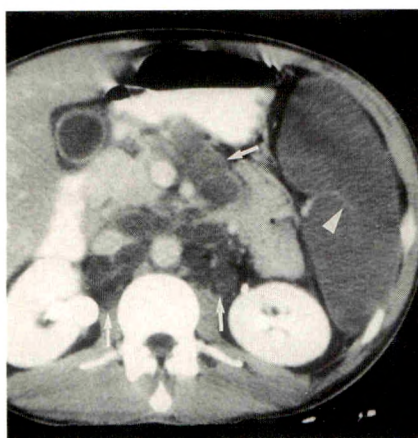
CT scan shows enlarged spleen of homogeneous low density. Enhancing vessels (arrowhead) course through splenic parenchyma. Multiple enlarged lymph nodes of diffuse homogeneous low density (arrows) are seen in retroperitoneum and mesentery. Blood culture, bone marrow biopsy, and submandibular lymph node biopsy yielded *Histoplasma capsulatum*.
